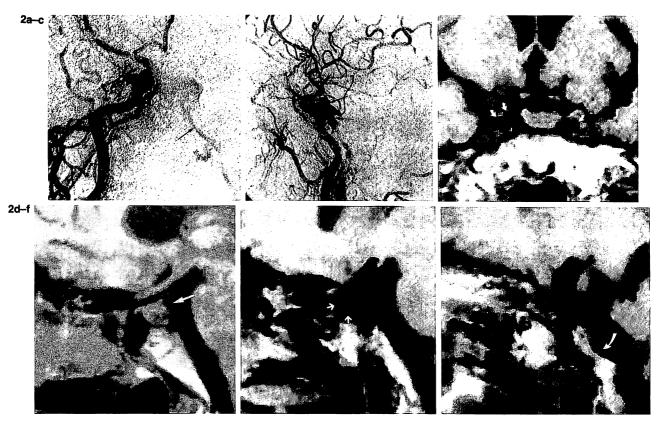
Case 6. A 69-year-old woman with right retroorbital pain and oculomotor and abducent nerve palsy (c-f are T1-weighted spin echo images with TR 600 and TE 40 ms). a: This right common carotid injection (anteroposterior view) demonstrates the dural arteriovenous fistula at the cavernous sinus (CS). Feeders are the artery of the foramen rotundum, the middle meningeal artery, the ascending pharyngeal artery, and the meningohypophyseal trunk. Shunted blood drains into both inferior petrosal sinuses (arrows) and into the basilar plexus. b: Lateral view of same arteriogram shows shunted blood draining into the basilar plexus (arrows) and both inferior petrosal sinuses. c: Coronal image demonstrates signal void (arrows) around both intracavernous carotid arteries. d-f: These sagittal images are contiguous from the midline to the right side. d: Arrow indicates signal void in the basilar plexus. e: Arrows indicate right internal carotid artery, surrounded by signal void due to shunted blood in the CS. f: Arrow points to signal void in the right inferior petrosal sinus.
